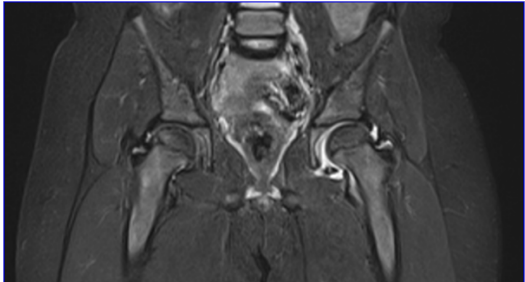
STIR coronal MRI of a female child shows left idiopathic chondrolysis of hip
